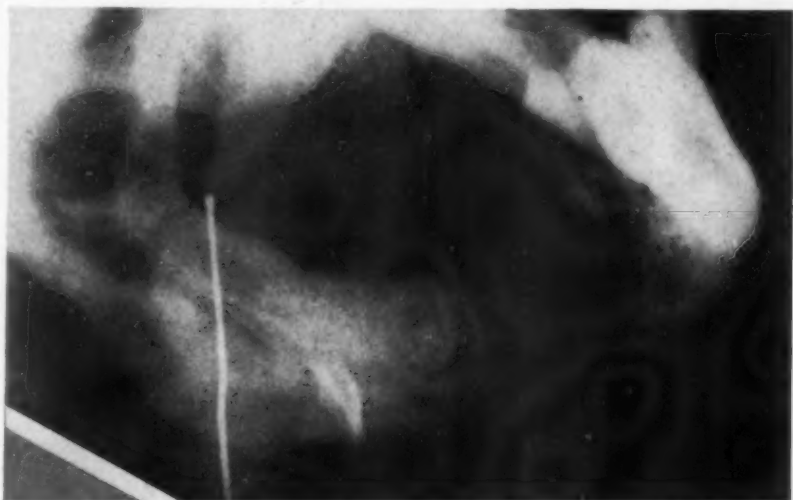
Lateral x-ray with probe inserted showing a sequestrum below the mandibular notch.
